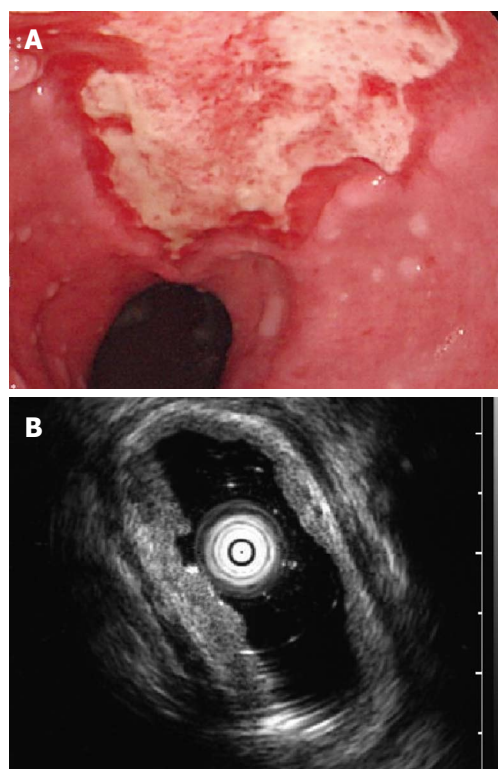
Esophagogastroduodenoscopy revealing a shallow ulcer without a tumor (A) and endoscopic ultrasound revealing thickening mucosal and submucosal layers, an intact muscularis propria layer, and no submucosal tumor (B) during the follow-up one week later.
